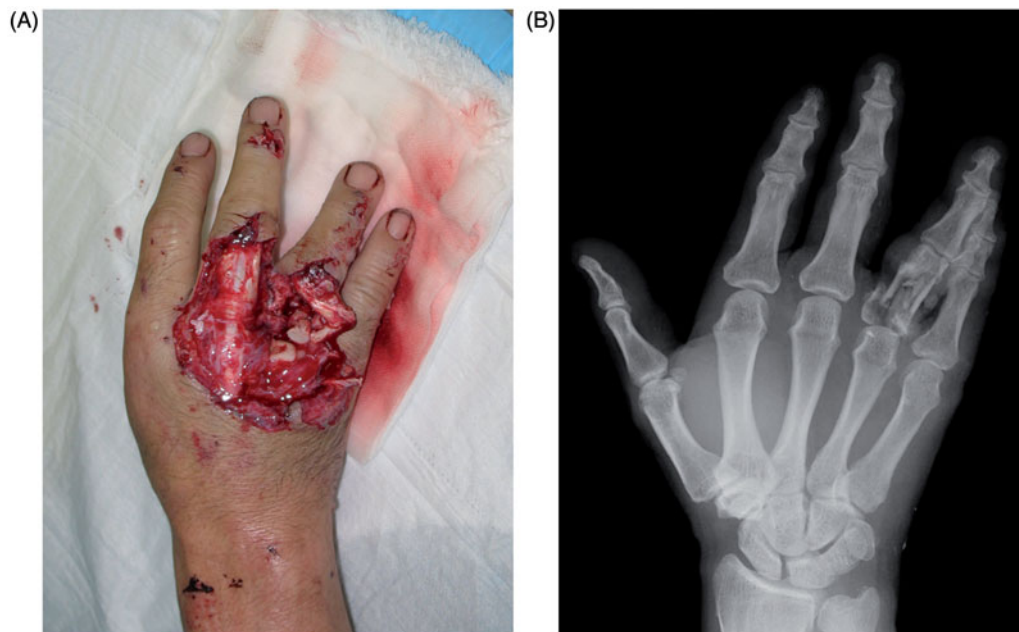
Case 1: right hand on initial presentation. (A) Dorsal view showing the skin defect. (B) X-ray revealing a comminuted fracture of the ring proximal phalanx.
